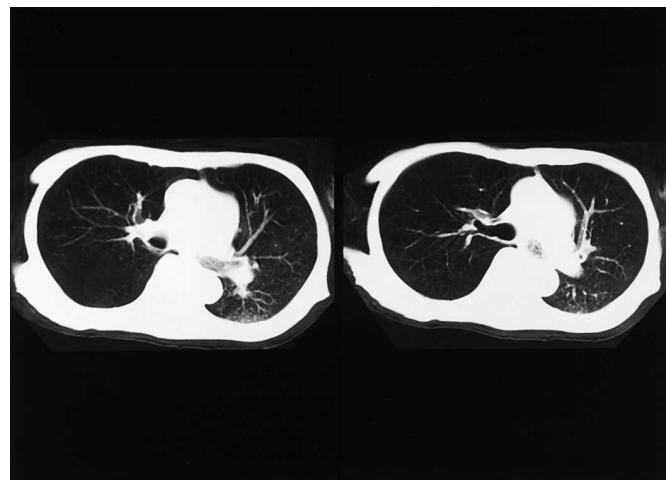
Chest computed tomography scan of the patient showed that the left main bronchus and its branches were filled with a foamy substance.
